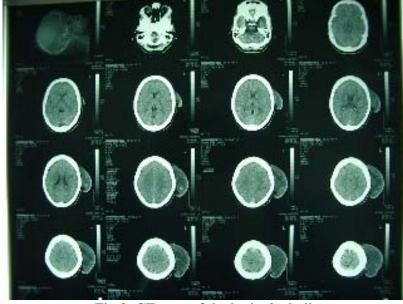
CT scan of the brain & skull
